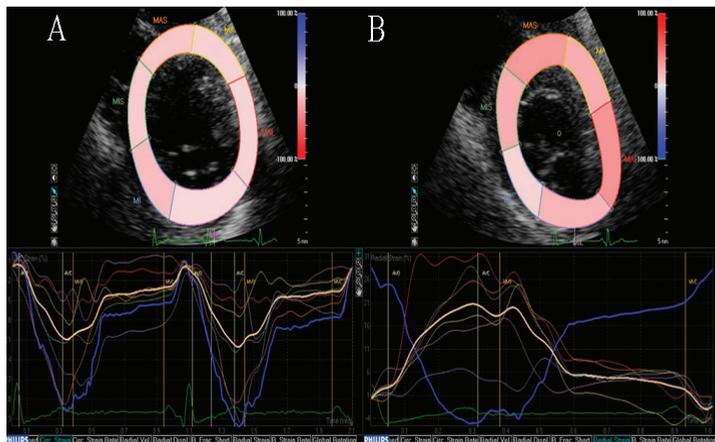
Strain measured by 2D speckle-tracking echocardiography. The LV circumferential (A) and radial (B) functions shown as digital curves in the short-axis views
